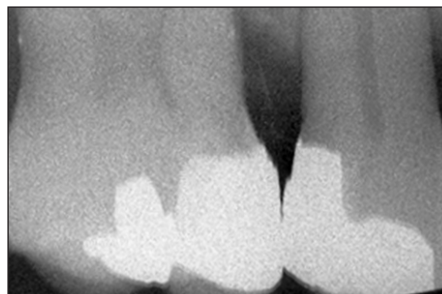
Radiographic image of the corrected restoration. Note minor damage to the adjacent restoration.
